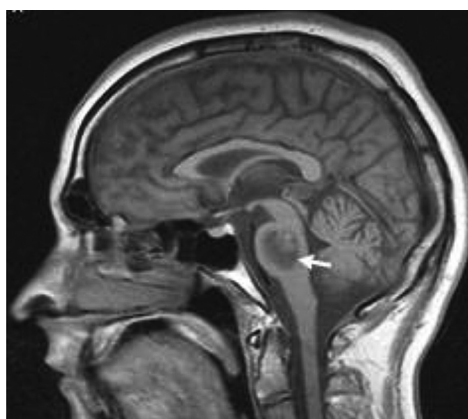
Brain MRI of the patient showing a low T1 signal intensity lesion (day 14).
